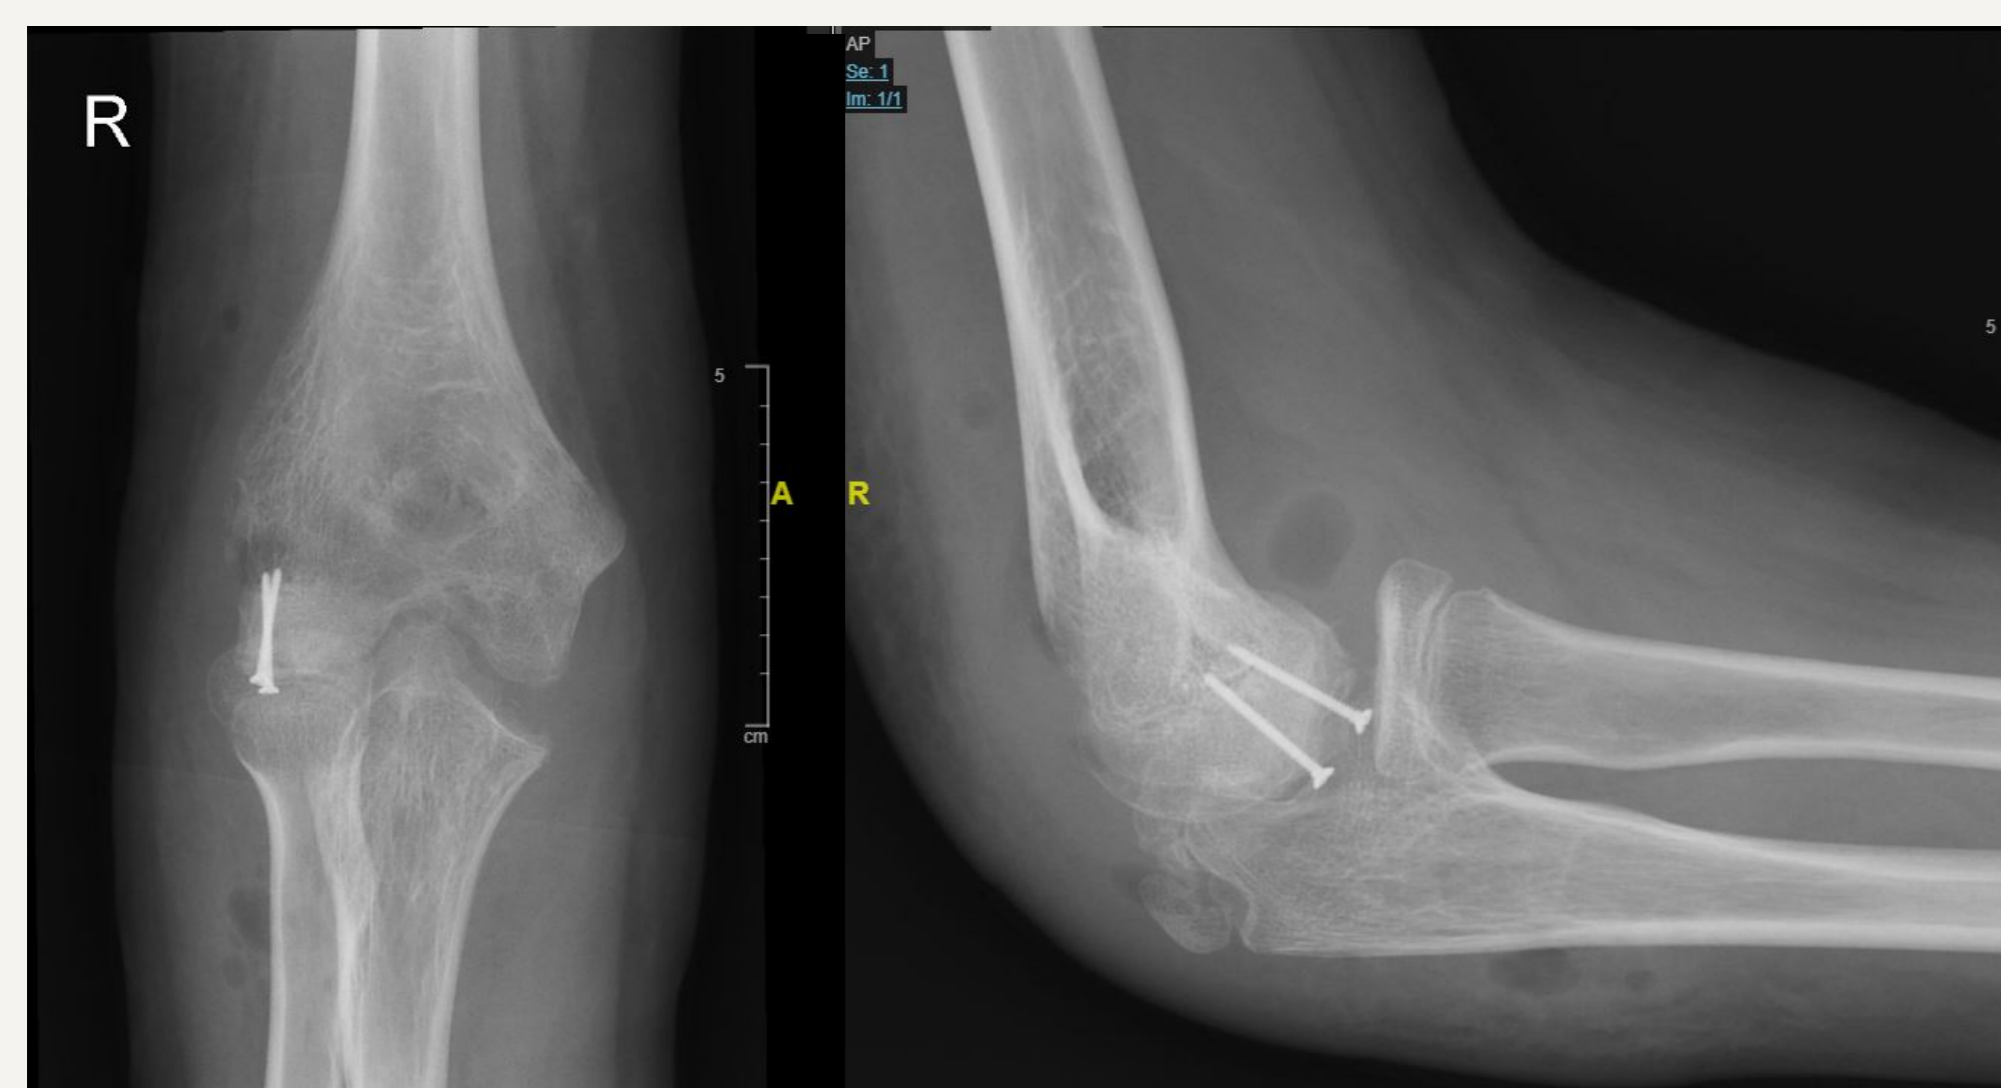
ap/lateral radiograph, 1 day postoperatively, reconstructed humeral capitulum by screw osteosynthesis, slight deformity of the humeral capitulum and olecranon
